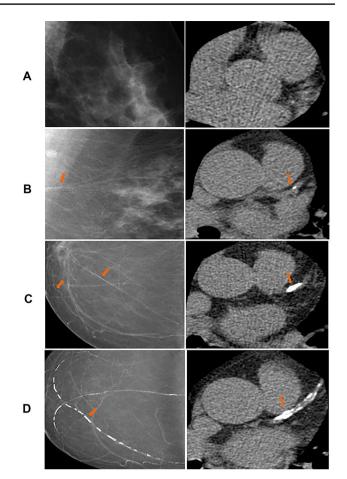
A A 49-year-old woman with normal mammogram with BAC grade=0 (left) and normal CT scan with Agatston score=0 and CAD-RADS=0 (right). B A 65-year-old woman with mammogram with BAC grade=1 (left), CT scan with Agatston score=14, and CAD-RADS=1 (right). C A 82-year-old woman with mammogram with BAC grade=2 (left), CT scan with Agatston score=163, and CAD-RADS=2 (right). D A 83-year-old woman with mammogram with BAC grade=3 (left), CT scan with Agatston score=550, and CAD-RADS=3/N (right). Arrows show to arterial calcification. BAC, breast arterial calcium; CAC, coronary artery calcium; CT, computed tomography
